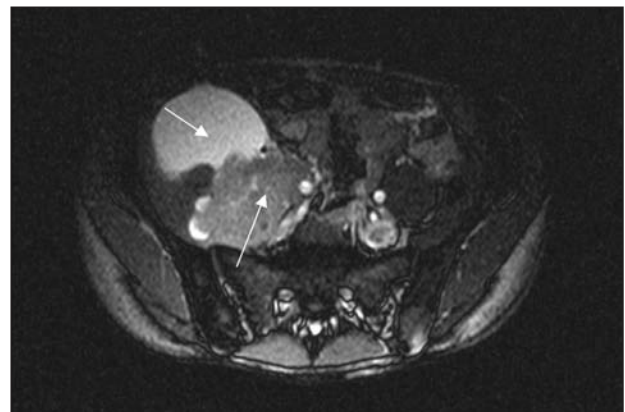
Axial T2 weighted MR image demonstrating the cystic (long arrow) and solid (short arrow) mass.
